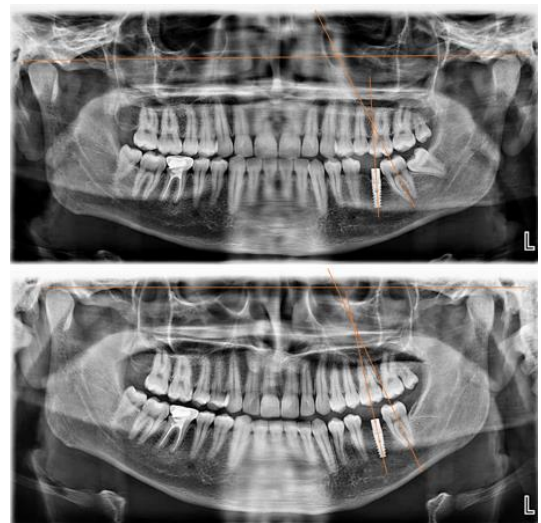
Radiographic interpretation of pre and post treatment OPG demonstrating uprighting of 37 and space regaining (Apparent change in implant inclination could be attributed to the combination of angular distortions in horizontal and vertical dimension in OPG)
